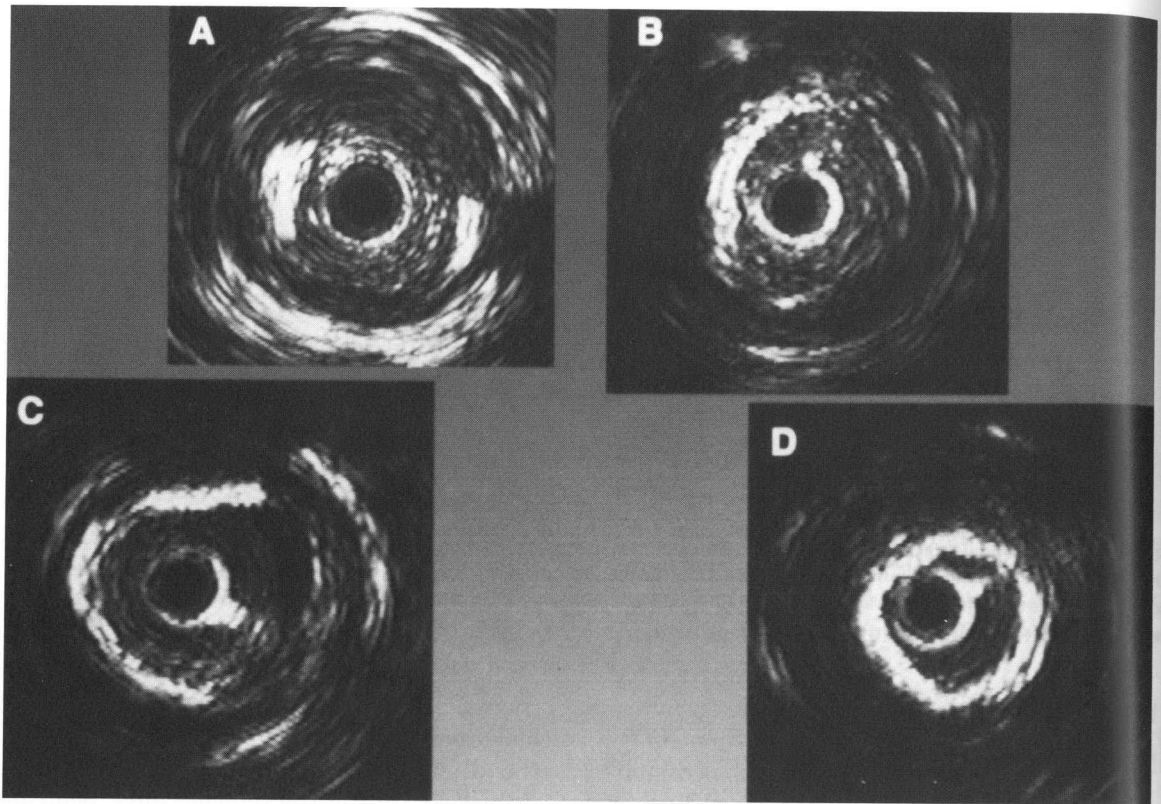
Varieties of calcification as seen with intravascular ultrasonic imaging. Calcified plaques have various morphologic patterns ranging from small patches of calcium to concentric bands that may take up the entire circumference of a portion of the plaque. These bands may be at the interface between the lumen and the plaque (D) or may be buried deep within the substance of the plaque closer to the media (A).
